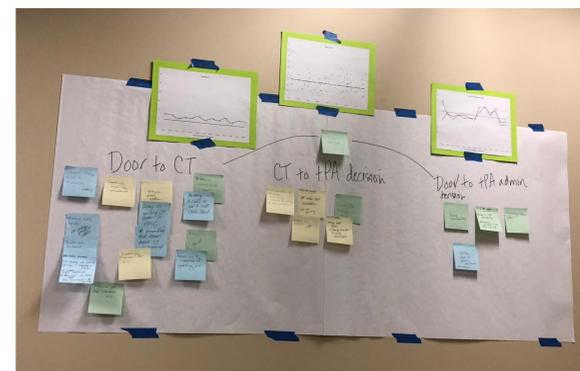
Sorting the identified barriers to the three main segments of alteplase administration: Door to CT, CT to alteplase decision, and door to alteplase administration.
